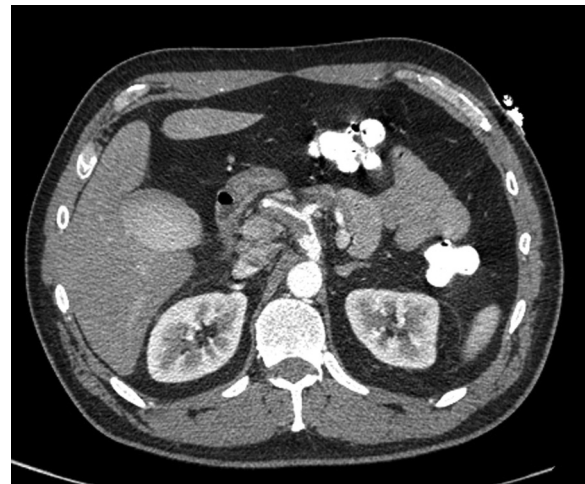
Computed tomography angiogram (CTA) demonstrates a celiac artery dissection extending into the common hepatic artery. The false lumen is thrombosed.
